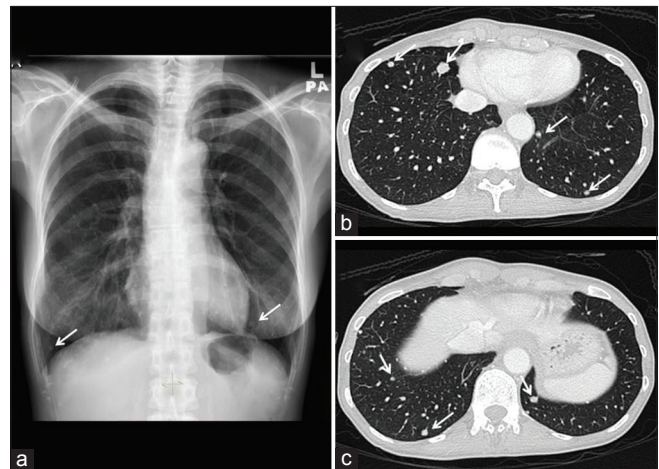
Chest X-ray (a) revealed two lung nodules in both lower lobes. Contrast-enhanced computed tomography thorax in lung window showed multiple lung nodules in both lower lobes of varying sizes in (b) and (c) in keeping with metastases
